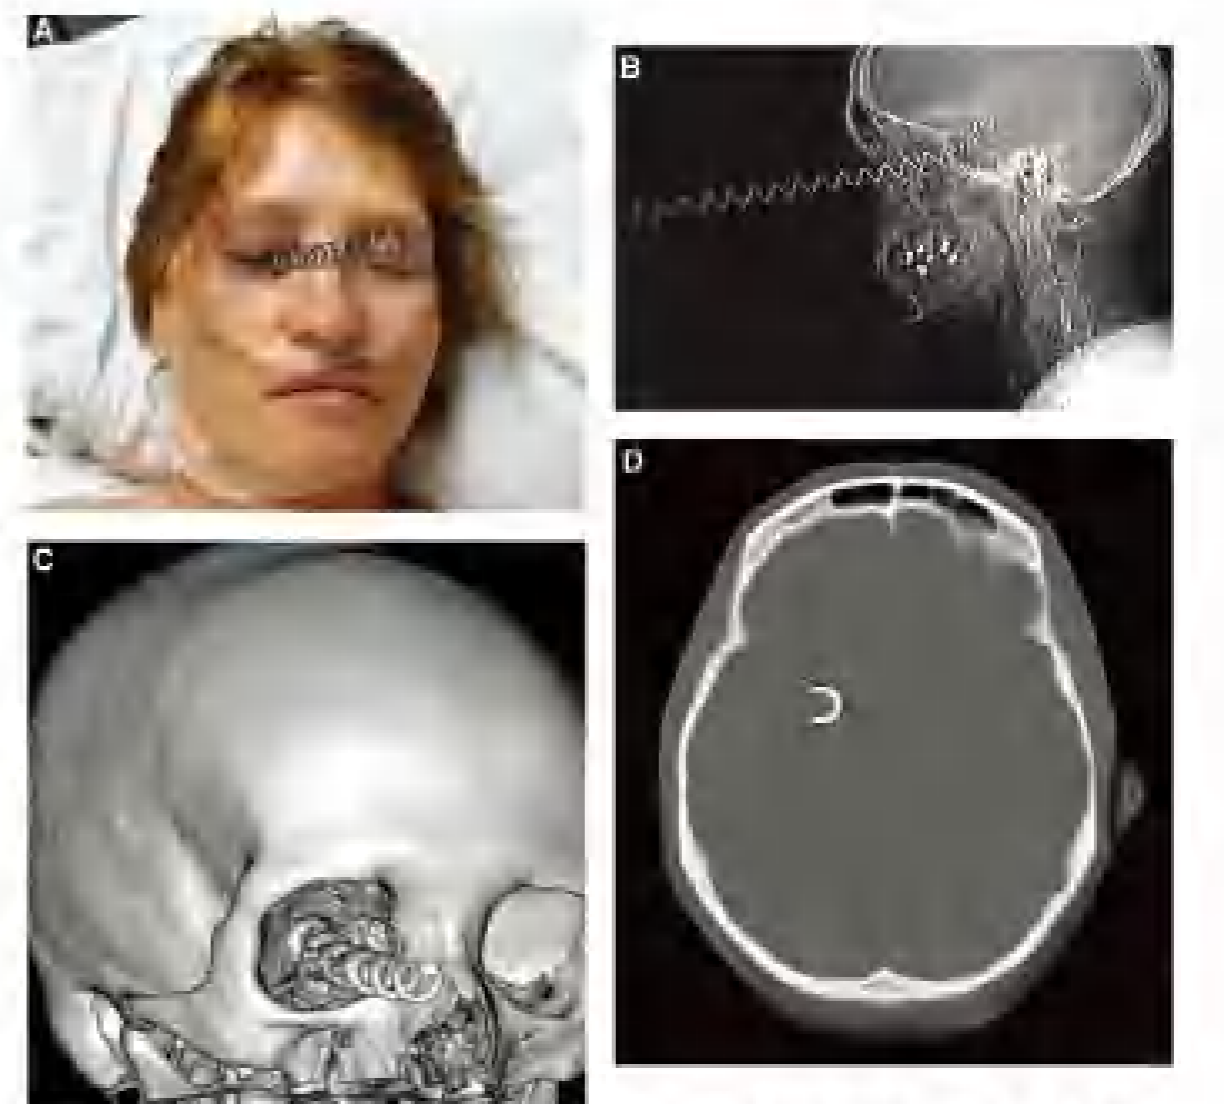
A, External photograph demonstrating a large metallic spring penetrating the right orbit (inferior to the globe). B, Lateral skull X-ray depicting the spring penetrating through the orbit and into the brain. C, Three-dimensional volumetric reconstruction showing the spring penetrating through the orbit and into the superior orbital fissure. D, Axial CT scan showing deep penetration of the metallic spring in the brain.
